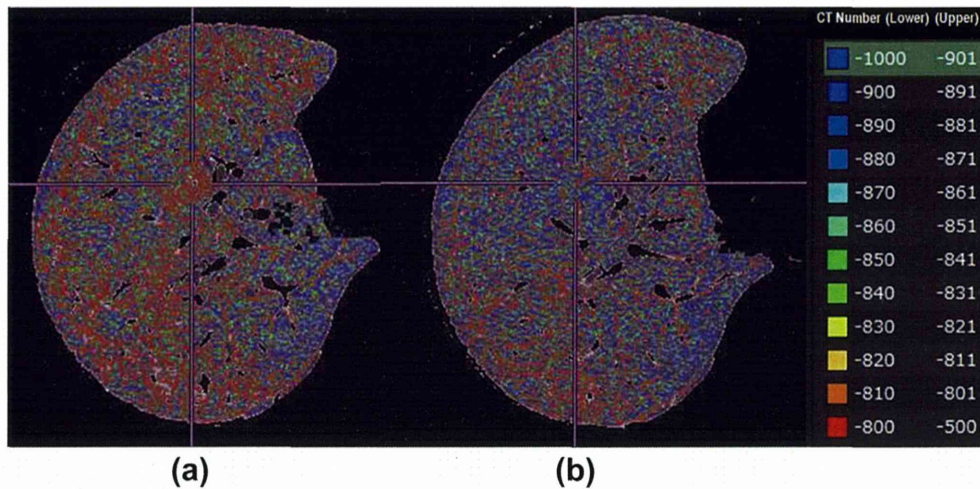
A 48-year-old woman with SSc. (a) CT densitogram indicates areas with radiodensity values over -800 and less than -500 in red. Quantitative analysis of the extent of %GGO before PBSCT is 43%. (b) Areas in red apparently decrease after PBSCT on the CT densitogram. Quantitative analysis of the extent of %GGO 1 year after PBSCT is 28%.
